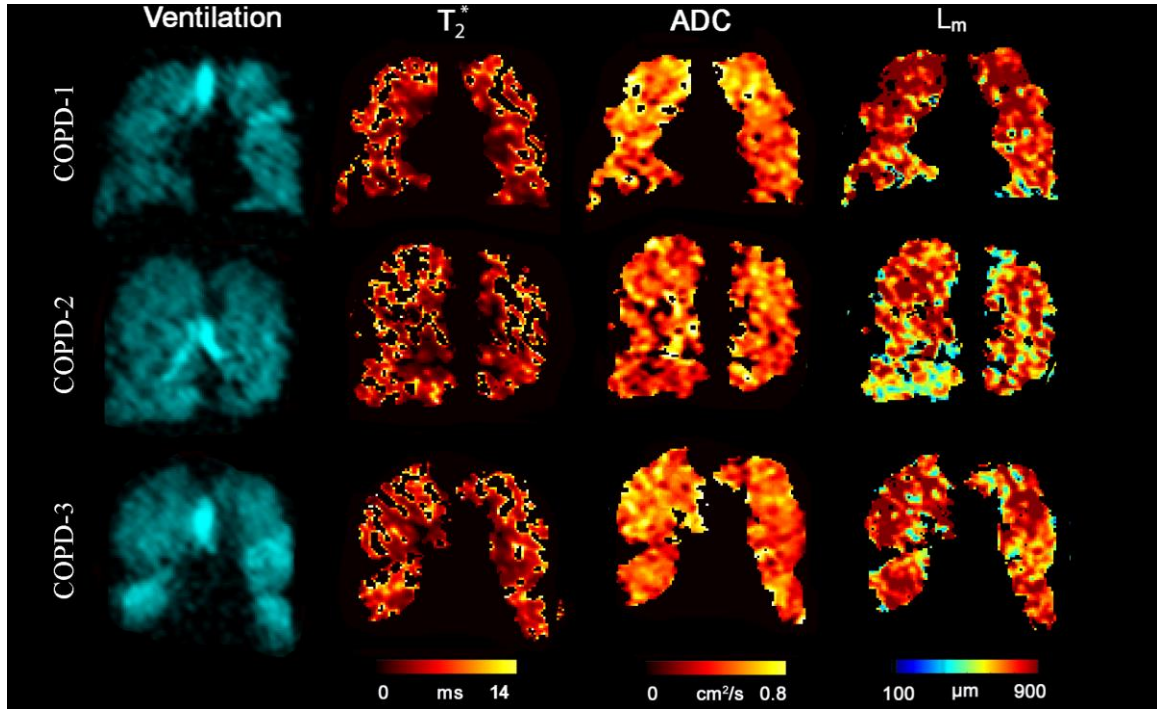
Representative ^3He MRI Maps obtained for COPD patients
